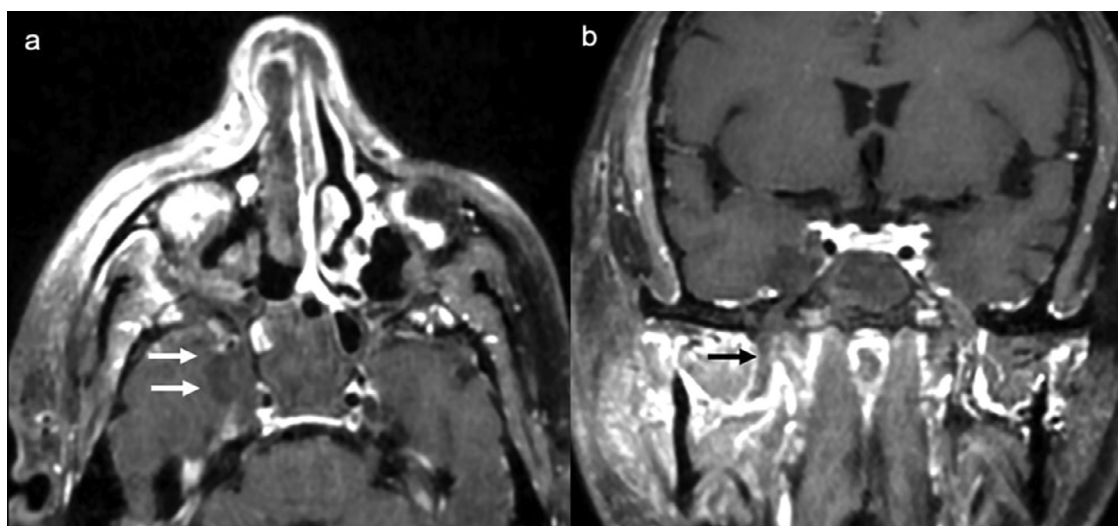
Post contrast T1 weighted MRI images of a patient with Rhino-Orbito-Cerebral Mucormycosis (ROCM) (a) Axial image shows abnormal enhancement extending from right retro-maxillary region with right cavernous sinus invasion, adjacent right temporal lobe invasion (white arrows). (b) Coronal image shows cavernous sinus invasion along with perineural spread of disease along the branches of right mandibular nerve (black arrow) through foramen ovale.
